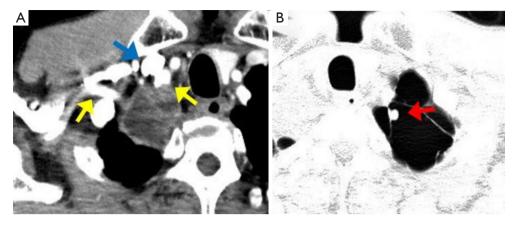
Chest computed tomography shows the location of the tumors. (A) The tumor is located in the right lung apex thoracic inlet adjacent to the right subclavian artery (yellow arrows) and the subclavian vein (blue arrow). (B) The tumor in the left lung apex on the bulla wall (red arrow).
